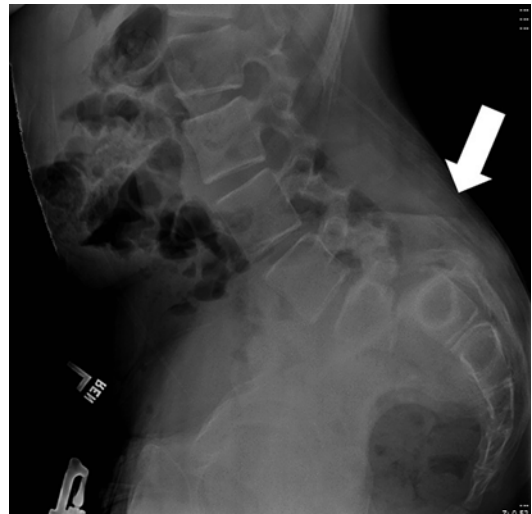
Lateral lumbosacral radiograph demonstrating the prominence of the posterior elements of the sacrum (white arrow) caudal to the spondylolisthesis. This area is easily palpated on exam due to prominence
